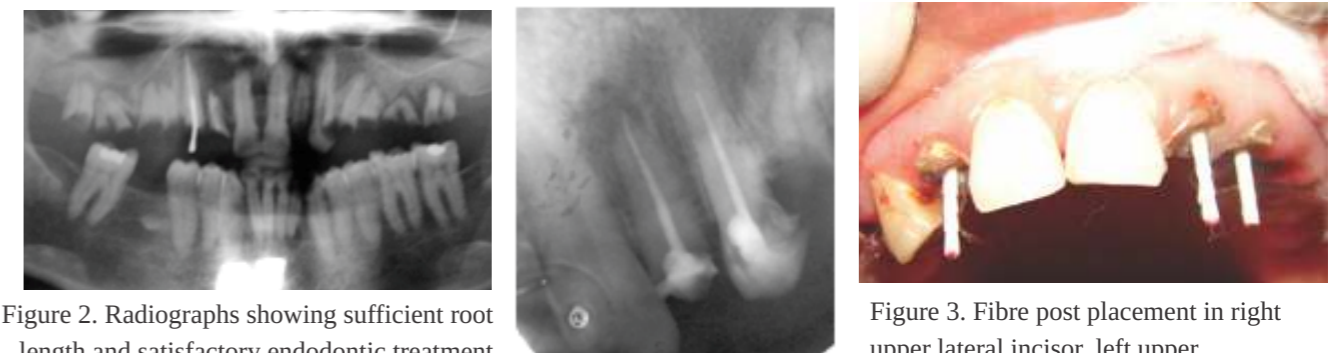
Radiographs showing sufficient root length and satisfactory endodontic treatment
